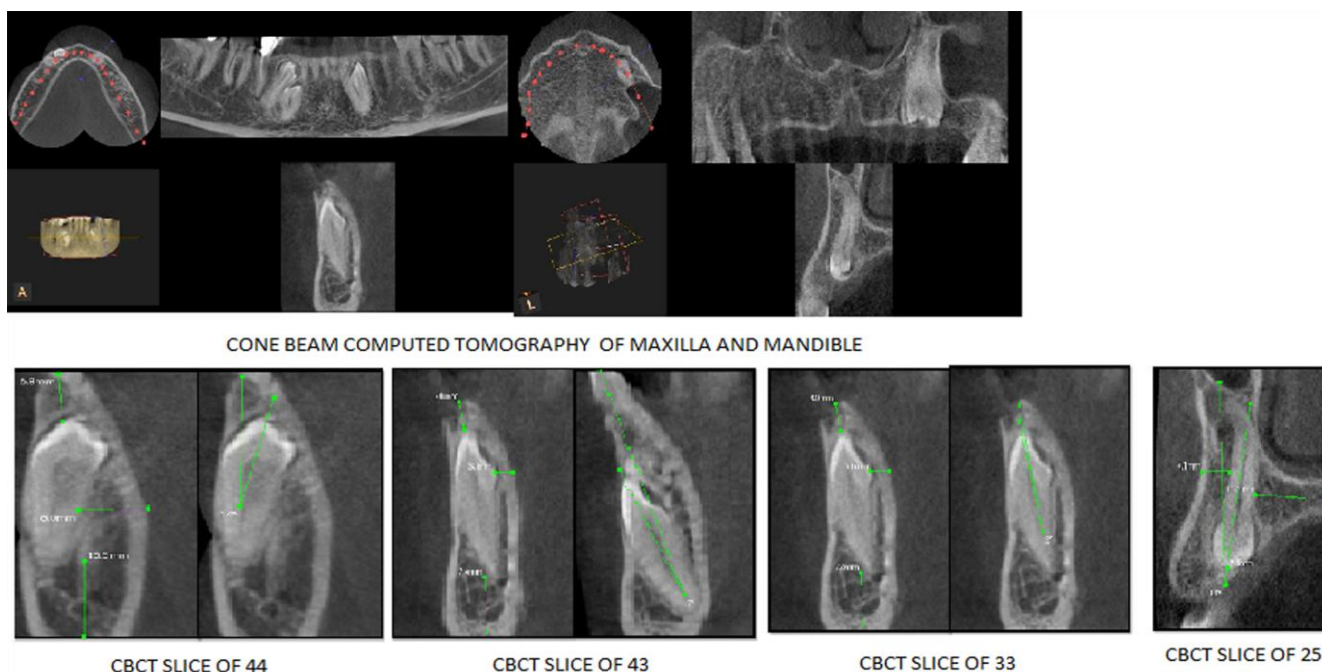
Cone beam computed tomography of maxilla and mandible
